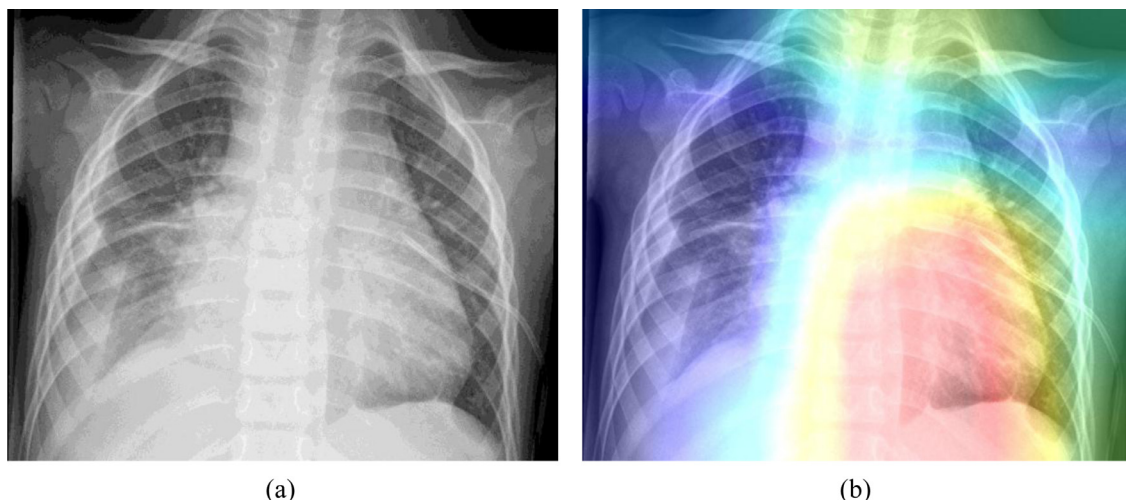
Chest X-ray image is input into the proposed network to output a heat-map based on: (a) the chest X-ray scan of the child with pneumonia, and (b) the visualization output.
